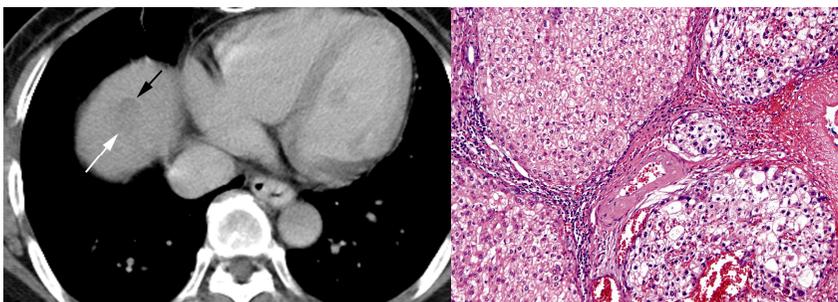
A 56-year-old female with early recurrent HCC after segmentectomy. The AFP level from a blood sample obtained the same day the CT scan was performed was 1076.84 IU/mL.
